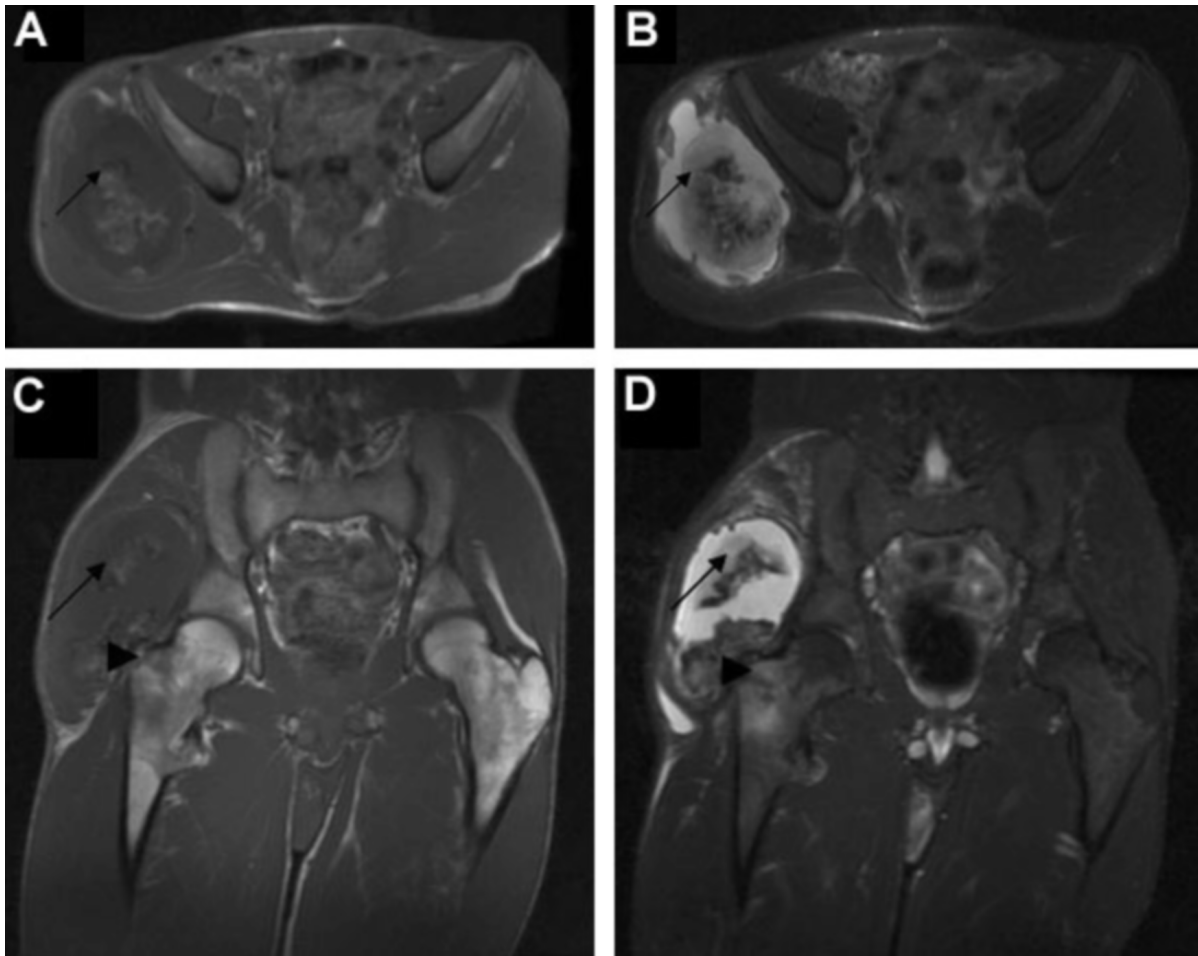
A-D (A-B) Transverse T1-weighted and T2-weighted and (C-D) coronal T1-weighted and T2-weighted MRI shows cartilage cap of osteochondroma (arrow) and fracture plane (arrowhead).
